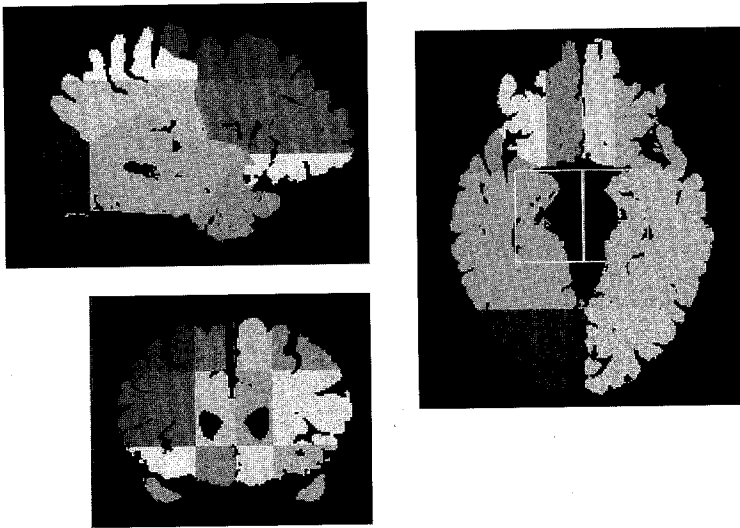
Color-coded regional parcellation mask superimposed on a healthy older adult's T1-weighted image shown in three planes. The box indicates the medial temporal region (including amygdala and hippocampus).
